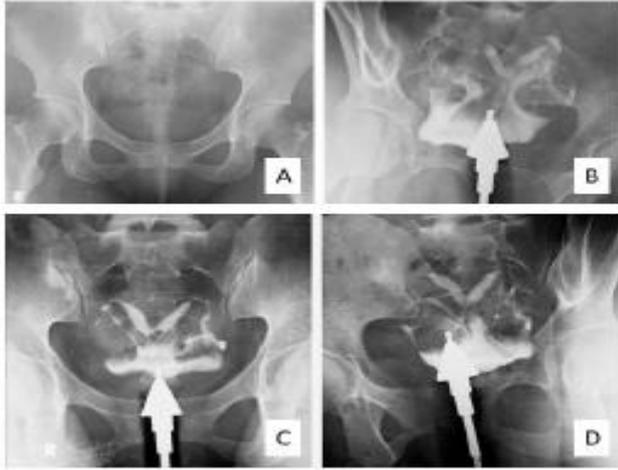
Bicornuate Uterus (A): Plain radiograph. (B): Contrast fills the cervical canal and uterine cavity, which is divided into two symmetric right and left parts, with smooth mucosal lining, and no persistent filling defects or additional shadows. (C): Contrast is seen filling both the right isthmus (continuous with the right uterine cavity) and the left isthmus (continuous with the left uterine cavity). (D): Contrast fills both fallopian tubes, with spillage (+) from both tubes.
